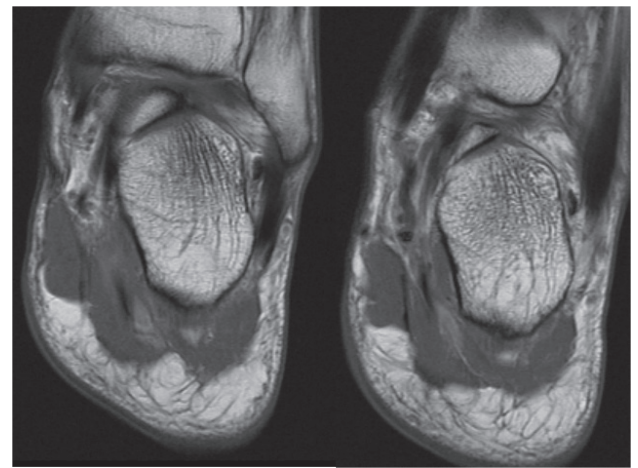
Consecutive coronal T1-w MR images.
